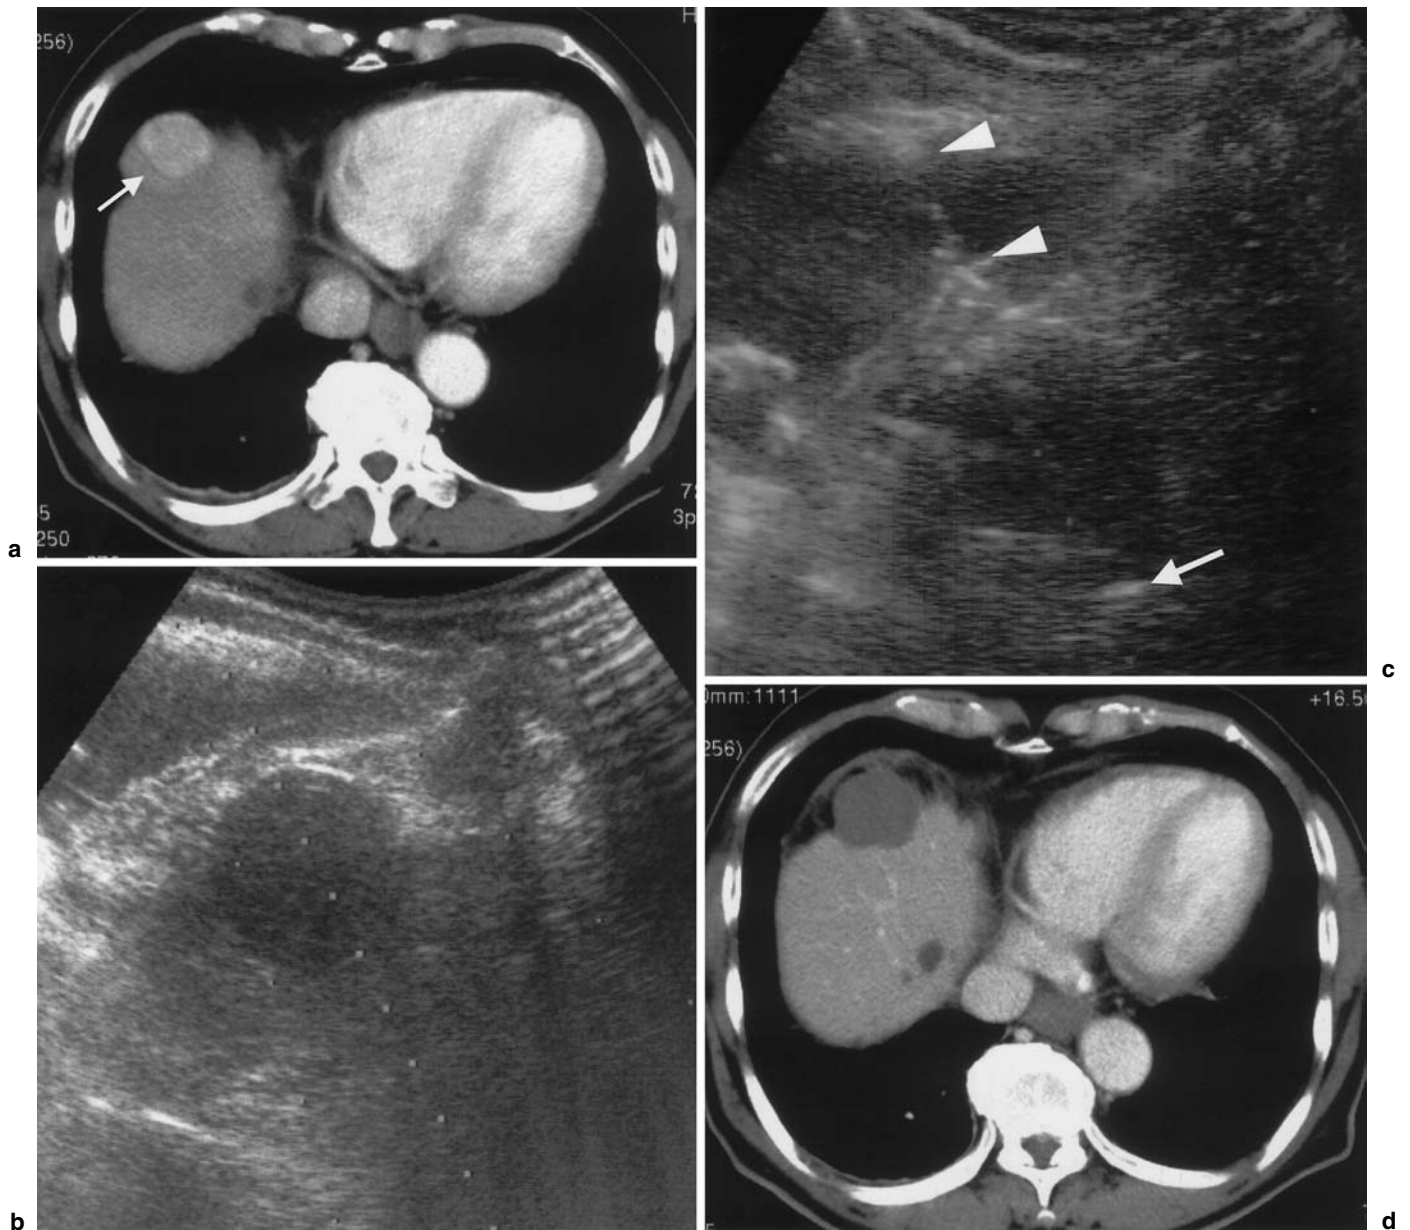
Findings in a 72-year-old man with hepatocellular carcinoma in the hepatic dome. a Early-phase dynamic computed tomography (CT) scan shows 3.0-cm diameter hepatocellular carcinoma (*arrow*) in enhanced area located in the right subphrenic region. b B-Mode ultrasonography shows the whole tumor located in the hepatic dome after the intrathoracic injection of a total of 1000 ml of 5% glucose solution. c B-Mode ultrasonography shows the radiofrequency electrode needle (*arrowheads*) penetrating the nodule of hepatocellular carcinoma; the top of the needle is indicated by the *arrow*. d Early-phase dynamic CT scan obtained 1 month after percutaneous radiofrequency ablation therapy shows that the tumor and surrounding area are not enhanced, thus indicating complete necrosis of the lesion
